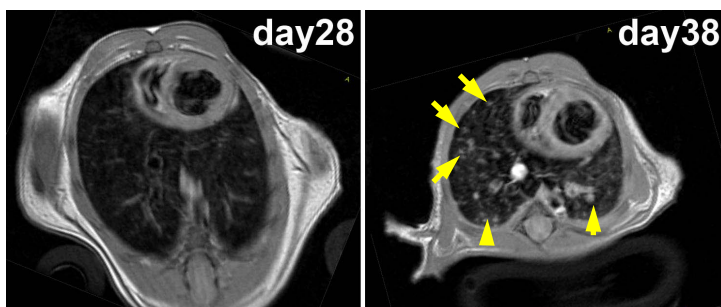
Lung metastases on MRI *in vivo*
